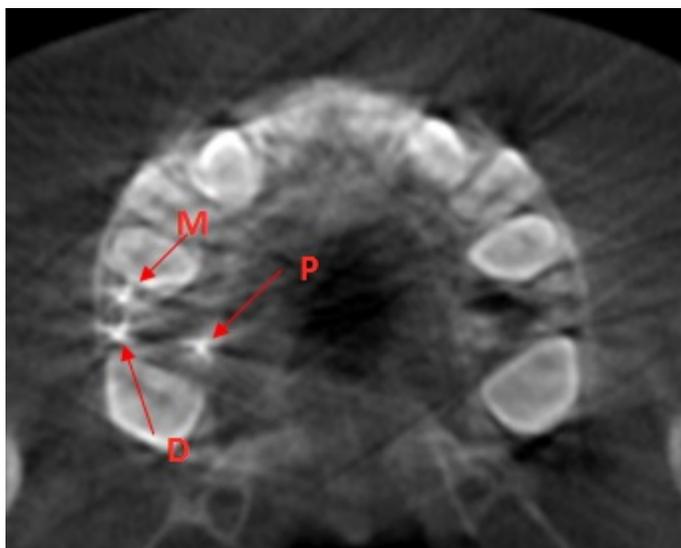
CBCT view of the maxillary right molar at apical third.
